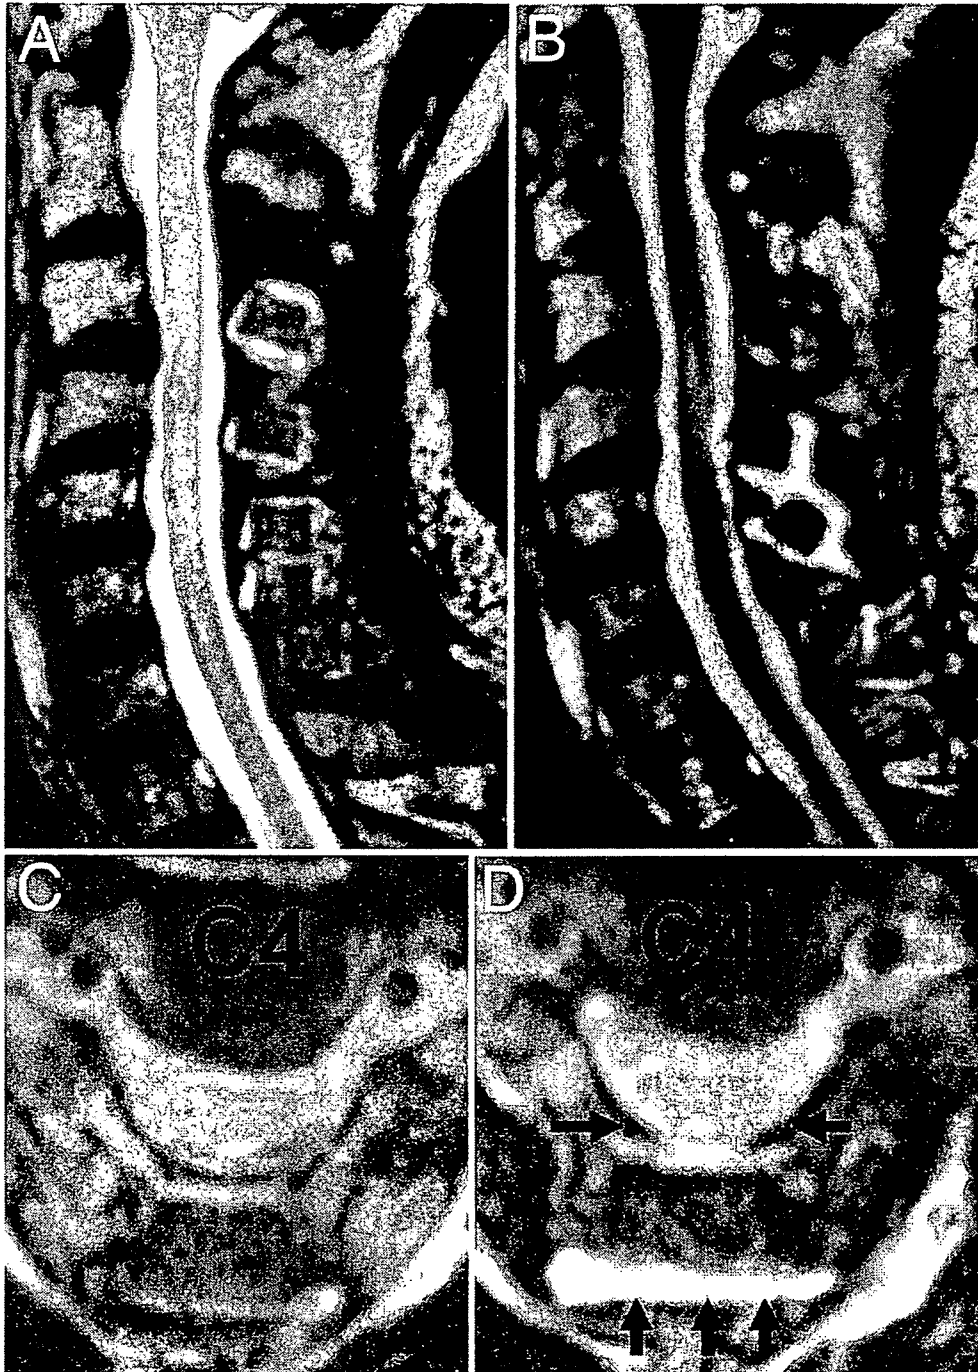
Case 2. Sagittal (A) and axial (C) MR images obtained 1 year postoperatively demonstrating a good result. Sagittal (B) and axial (D) MR imaging studies obtained 4 years postoperatively demonstrating liquorrhea (arrows) around the hydroxyapatite intraspinal spacers of C-4 and C-5.
